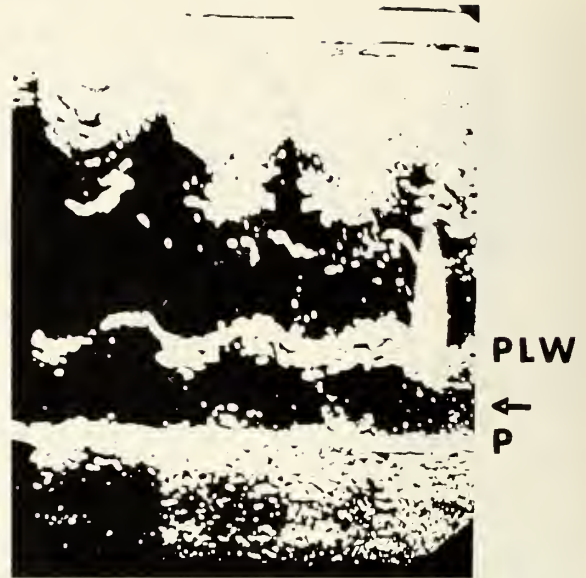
Echocardiogram in a patient with pericardial effusion showing the separation of the posterior left ventricular wall from the pericardium. The effusion is indicated by the echo-free space (arrow). 300 cc. of effusion was removed by pericardiocentesis.
